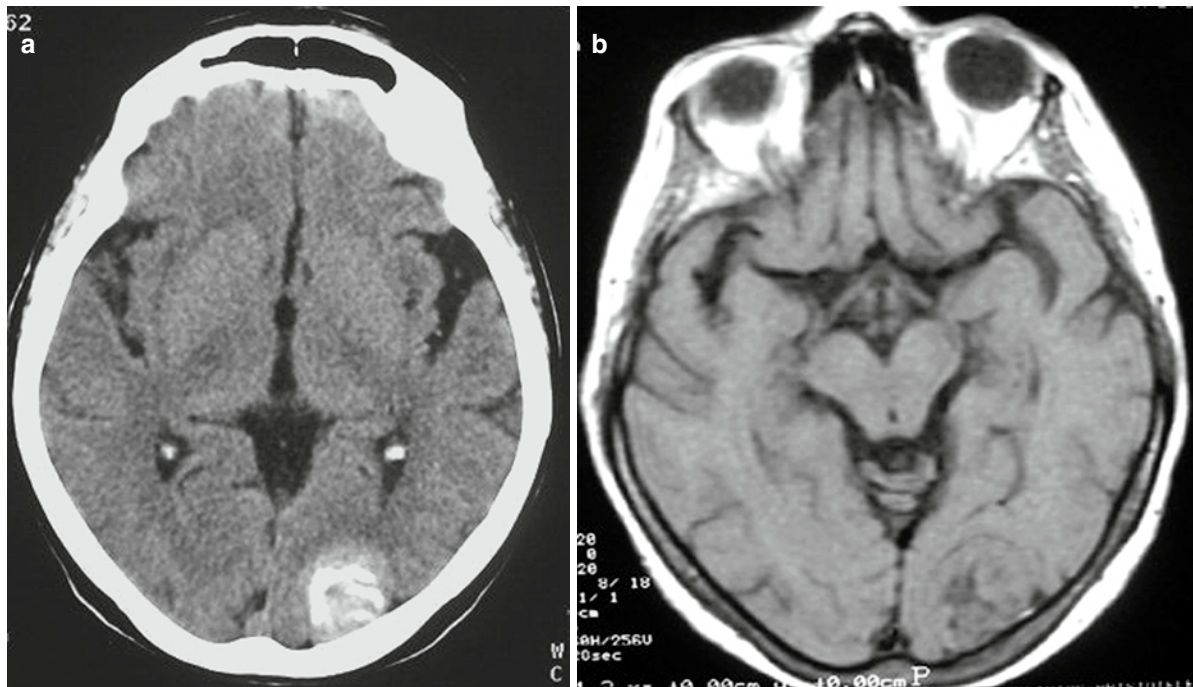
CT versus MRI in calcified meningioma. (a) Axial CT. (b) Axial T1-weighted MRI. Densely calcified tumor is clearly demonstrated on CT. Most calcification is isointense to brain on T1WI
